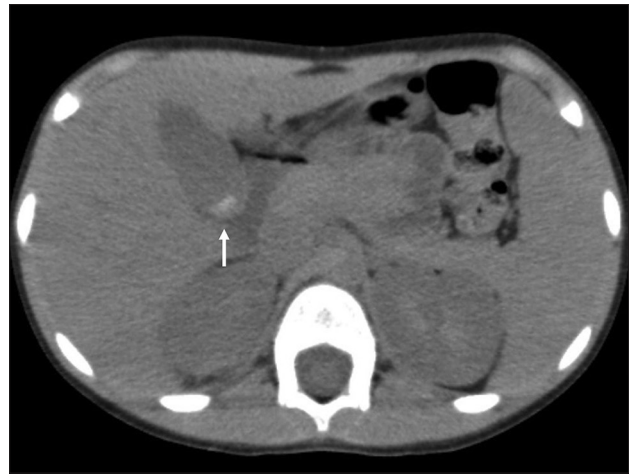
Axial noncontrast-enhanced computed tomography image showing gallstones within the gallbladder (arrow), with no signs of inflammation
